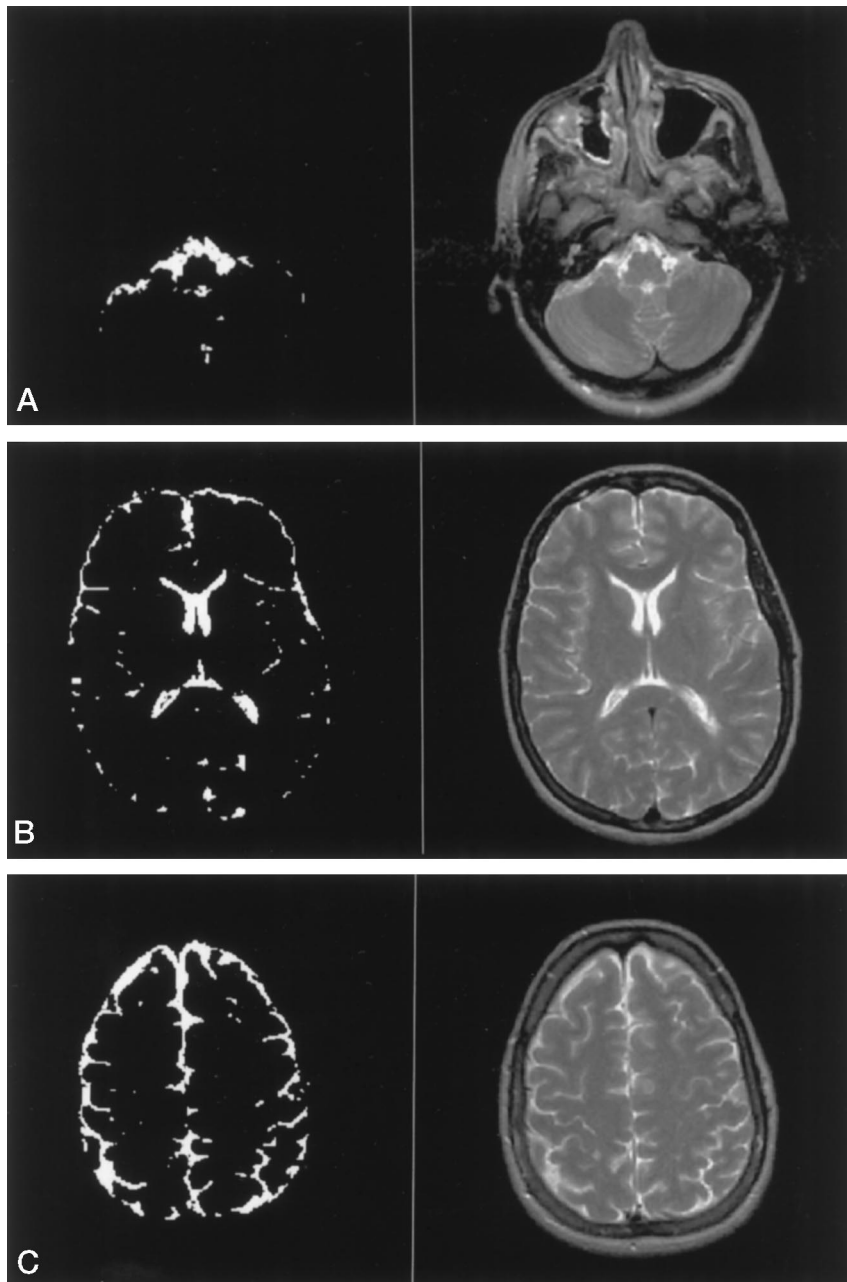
A–C, CSF-only images (*left*) and corresponding FSE T2-weighted (2500/90/1) images (*right*) at the level of the posterior fossa (A), lateral ventricles (B), and cerebral convexities (C).
